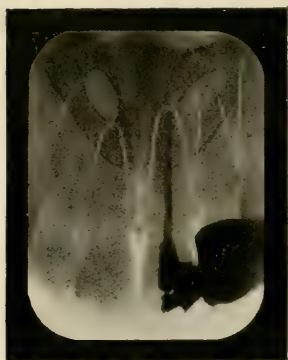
Radiograph showing the tip of the nose and the two nostrils, which latter have somewhat the appearance of abscesses of the lateral incisors. (Retouched.)
